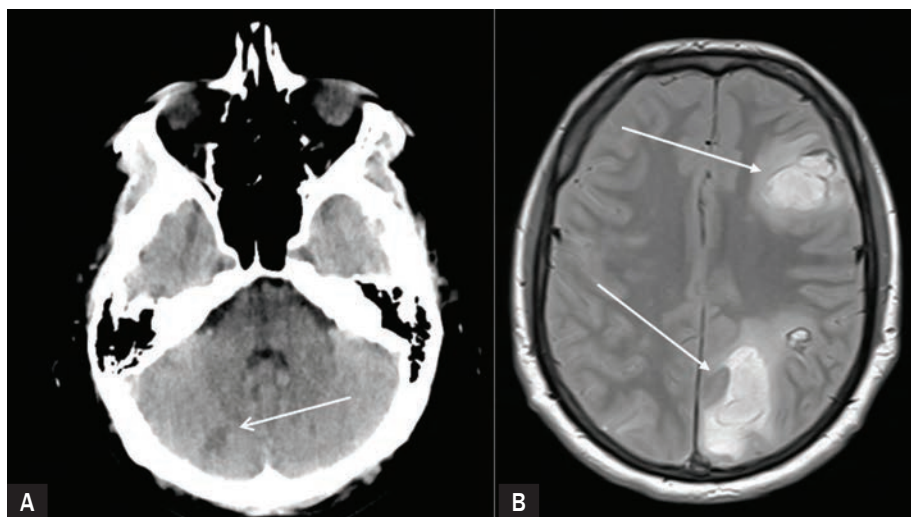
Results of imaging diagnostic procedures: A. Computed tomography (CT) – hypodense structure in the right cerebellar hemisphere; B. Magnetic resonance imaging (MRI) in T2 fluid-attenuated inversion recovery (FLAIR) sequence – hyperintense areas in the frontal and occipital lobe of the left hemisphere)
